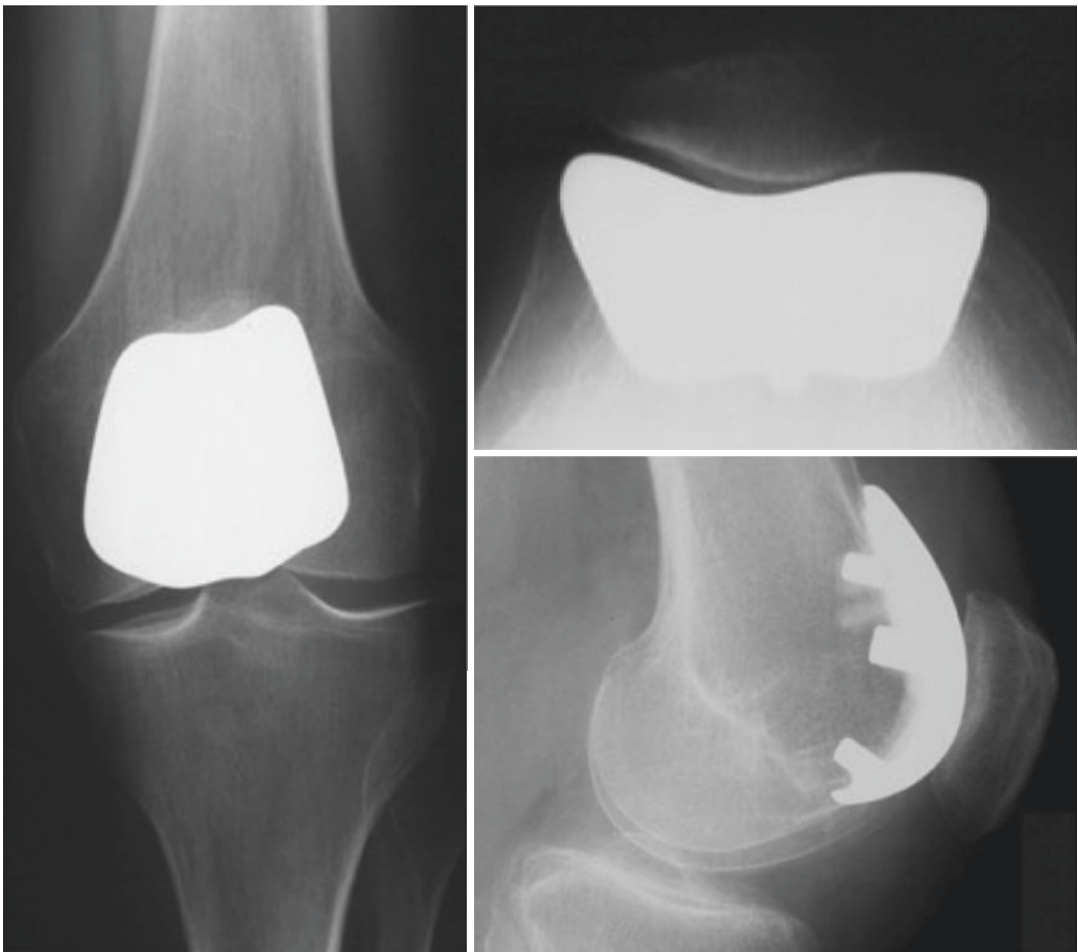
Postoperative radiographs of the onlay implant in three planes are done routinely to check implant positioning
